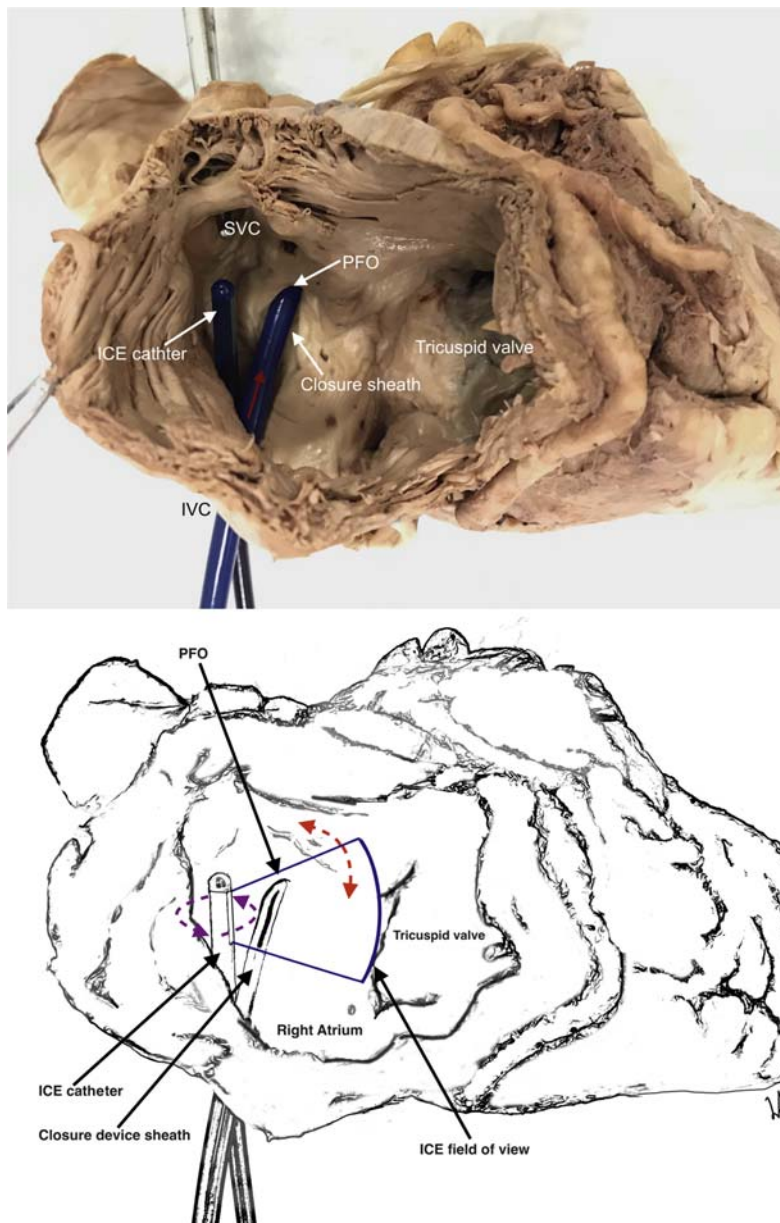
(Top) Image of the right atrium showing the location of a PFO within the fossa ovalis, and position of the intracardiac echocardiography (ICE) imaging catheter and closure device in relation to the septum, superior vena cava (SVC), and inferior vena cava (IVC). The red arrow indicates the flow of blood from the IVC toward the PFO. (Bottom) Depiction of the right atrium and location of the ICE catheter imaging field of view as it is used to scan across the different anatomical planes of the right atrium.
